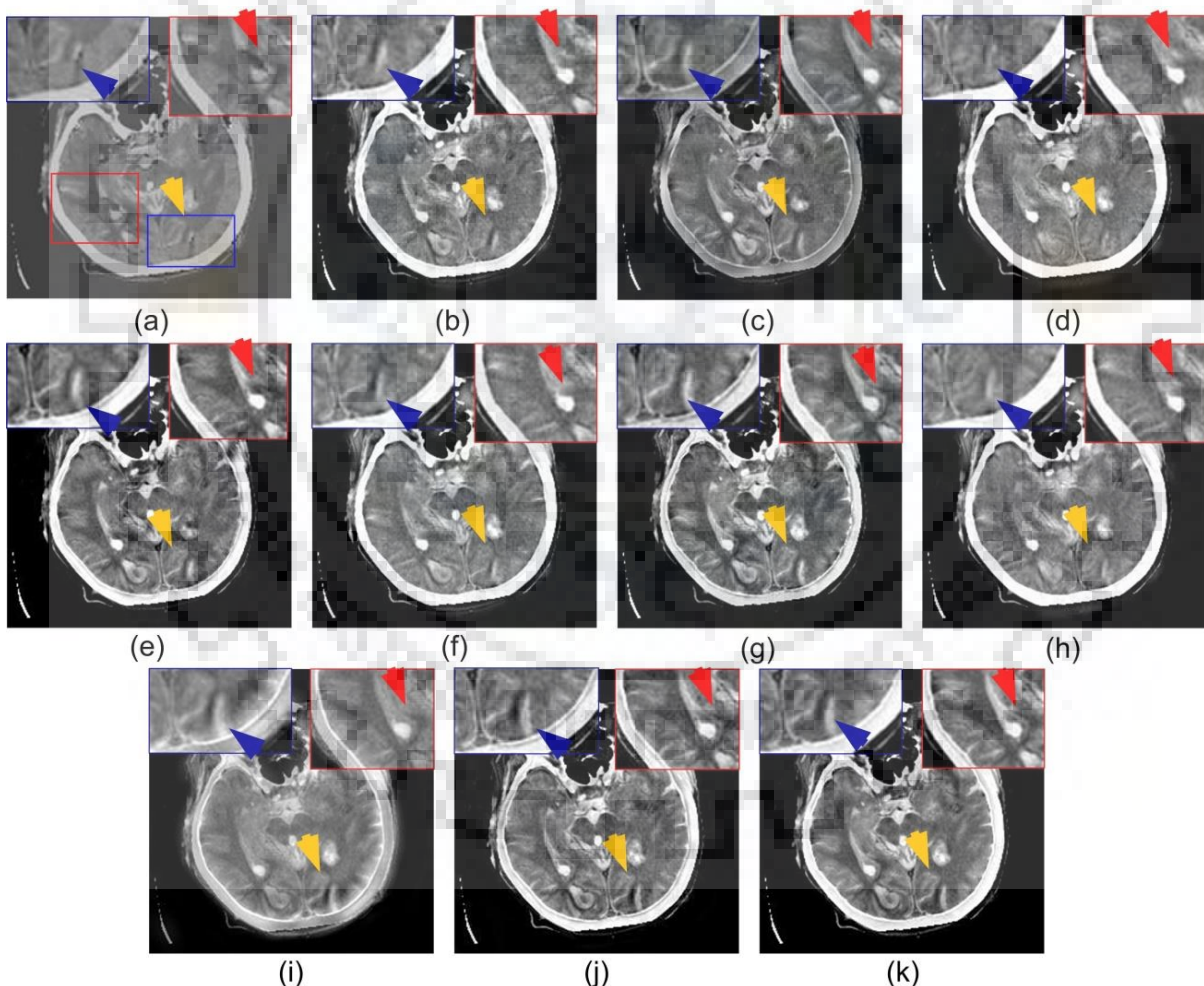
CT-MR image pair-1 shown in Figure 6.5. Comparison of fused images obtained by (a) Nirmla et al., 2016 [137] (b) Das and Kundu, 2012 [34] (c) Li et al. (GFF), 2013 [94] (d) Ganasala and Kumar, 2016 [48] (e) Yang et al., 2017 [203] (f) Zhu et al. (HMSD-GDGF), 2018 [218] (g) Liu et al., 2017 [111] (h) C-MIF method (i) Hermessi et al., 2018 [57] (j) Hou et al., 2019 [59] (k) Proposed CNN-MIF
